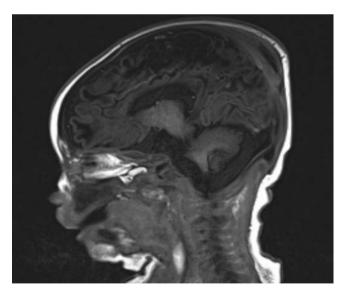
Brain MRI of a 5-day-old infant with molybdenum cofactor deficiency type A. The features are those of cystic encephalomalacia with multiple cysts in the subcortical white matter. An occipital subdural collection can also be seen
